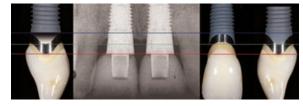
Radiographic evaluation of the radiograph presented in the article, comparing it with landmarks on the NobelPerfect implant: interproximal top of implant shoulder (*red line*); interproximal top of bone apposition area and facial/palatal top of soft tissue apposition area (*green line*); top of facial/palatal bone apposition area and start of planar, ie, 360° around the implant bone apposition area (*blue line*).
